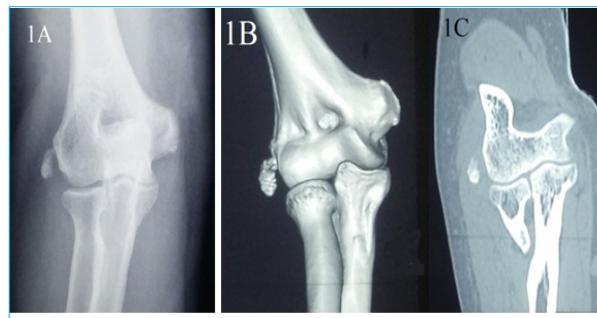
(A) Plain radiograph (B) 3-D CT scan and (C) Coronal CT scan, showing initial elongated hyperdense calcification in the lateral aspect of the lateral epicondyle.
